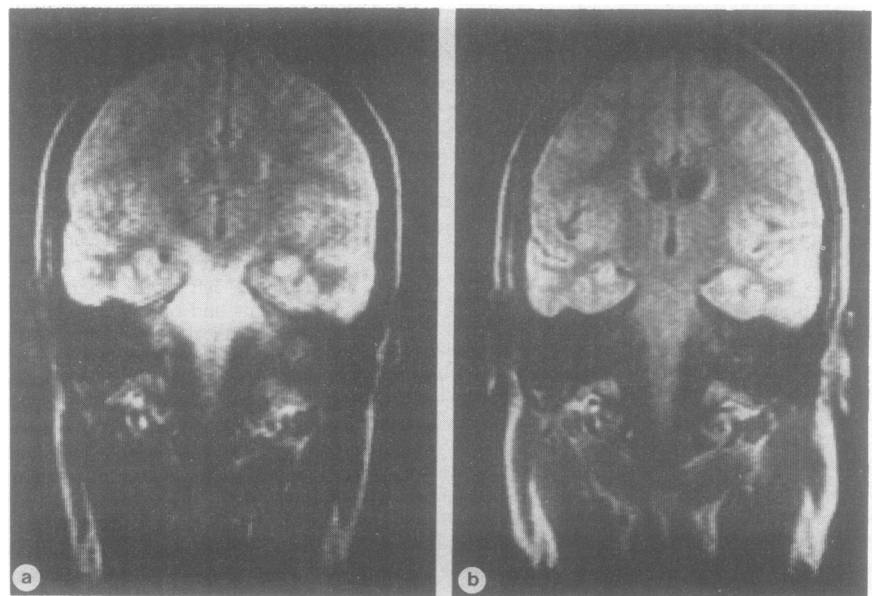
Figure (a) MRI of T2-weighted images showing a pathological area in the pons extending upwards to the cerebral peduncles and downwards to the medulla oblongata. (b) MRI performed two months later showing no abnormalities.
